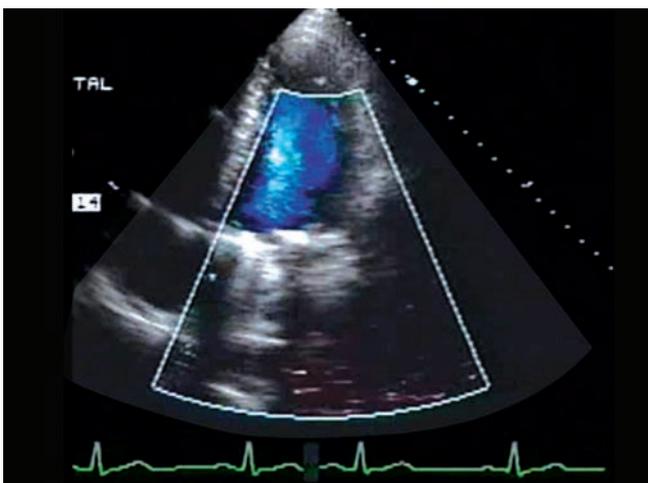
Color Doppler image of apical 4-chamber view.
